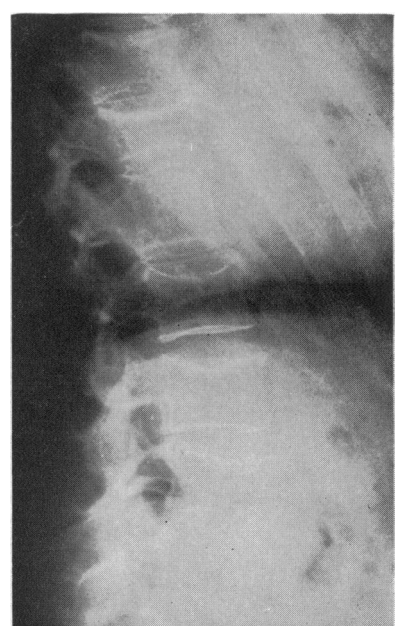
Radiograph of lumbar spine, August 10, 1957.
